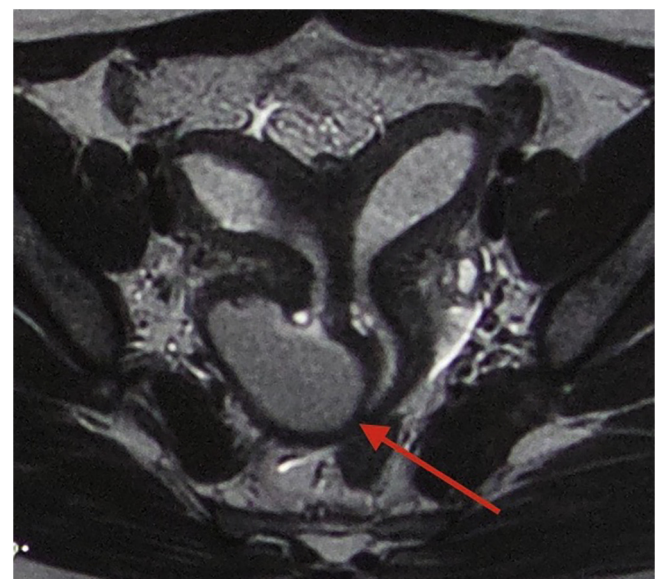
MRI result revealed two normal uterine corpuses with normal endometrium and normal cervix. The distal part of vagina seen obstructed with right cystic mass (haematocolpos) appearance.
